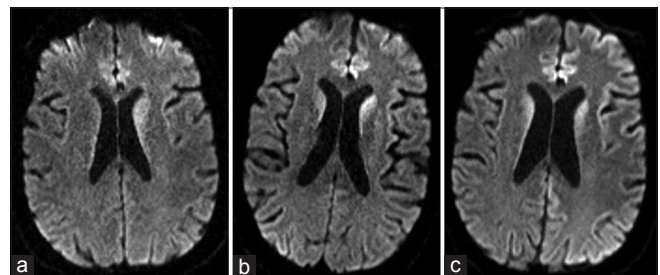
(a) Diffuse-weighted imaging images of patient's first magnetic resonance imaging was read as normal. However, on review, there is some restricted diffusion located in the left caudate and the cortical medial frontal lobes. (b) Diffuse-weighted imaging images on magnetic resonance imaging done 3 weeks after the first magnetic resonance imaging was read as restricted diffusion in the left putamen and left caudate greater than the right caudate, as well as restricted diffusion in the cortex primarily in the left frontal lobe concerning for Creutzfeldt-Jakob disease. (c) The last magnetic resonance imaging done 1.5 weeks after the last one showing the further progression of the restricted diffusion involving the cortex of the left parietal area
